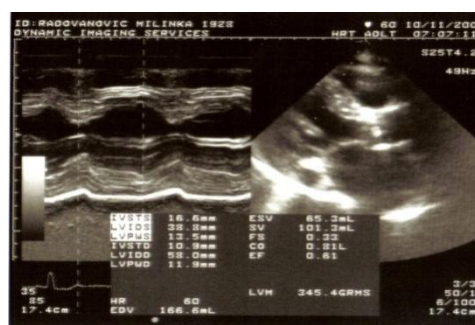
Echocardiographic image of a patient with extreme LVH of 345 g
